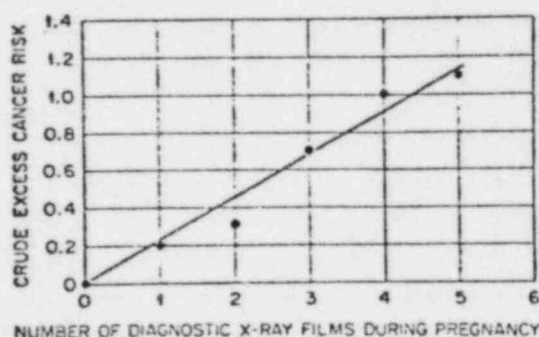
Relationship of cancer in children to the number of pelvic x-ray examinations received by their mothers during pregnancy. (Data from Alice Stewart and G. W. Kneale, *Lancet*, June, 1970).
